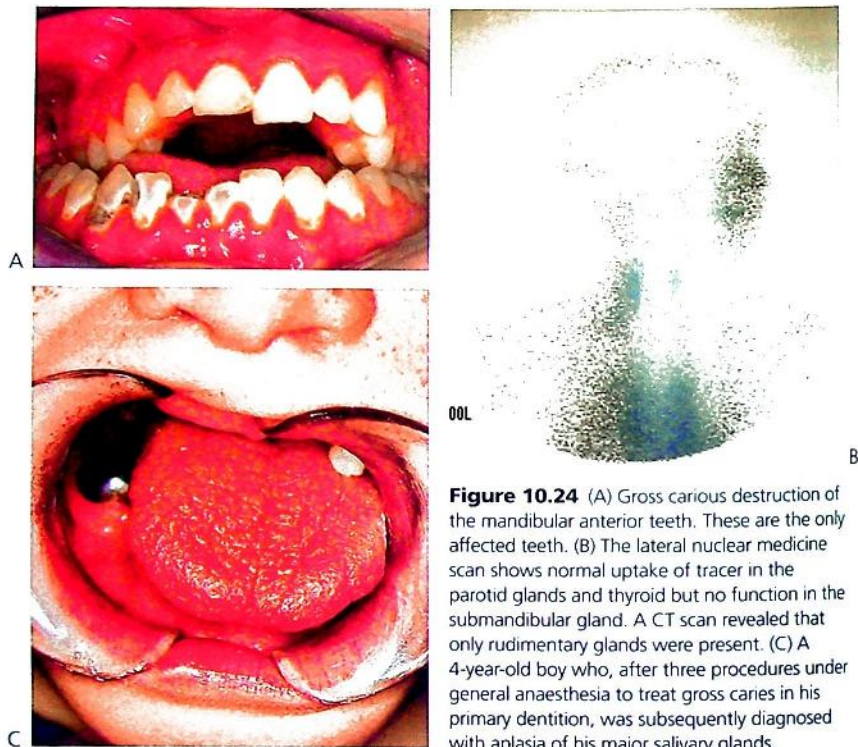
(A) Gross carious destruction of the mandibular anterior teeth. These are the only affected teeth. (B) The lateral nuclear medicine scan shows normal uptake of tracer in the parotid glands and thyroid but no function in the submandibular gland. A CT scan revealed that only rudimentary glands were present. (C) A 4-year-old boy who, after three procedures under general anaesthesia to treat gross caries in his primary dentition, was subsequently diagnosed with aplasia of his major salivary glands.
